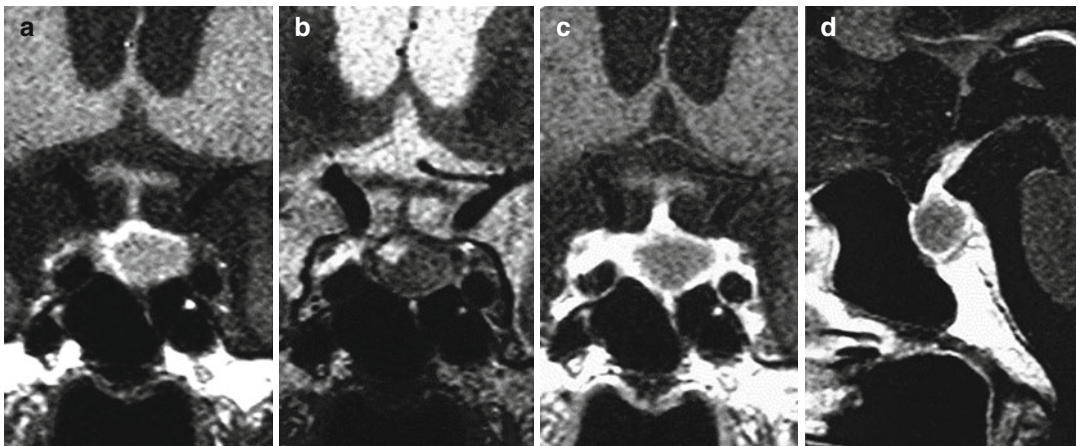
Coronal and sagittal MRI of RCC with hypophysitis (Komatsu et al. 2010). A 77-year-old man developed a 2-day history of panhypopituitarism. MRI showed an intrasellar cyst with isointensity on
